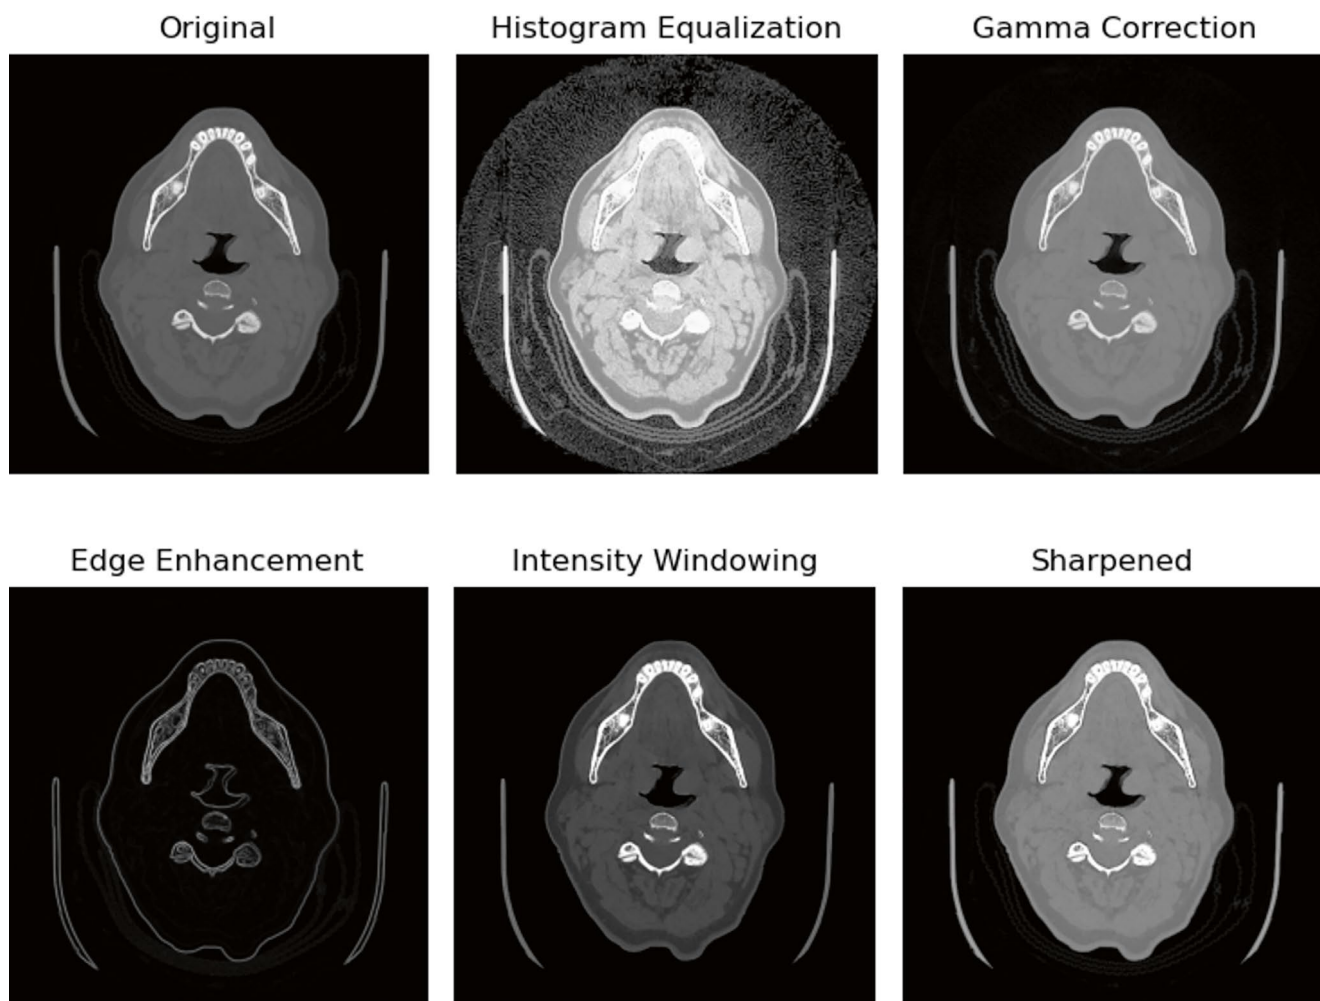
Visualization of image enhancement techniques applied to a CT image, including Histogram Equalization, Gamma Correction, Edge Enhancement, Intensity Windowing, and Sharpening. Each method
